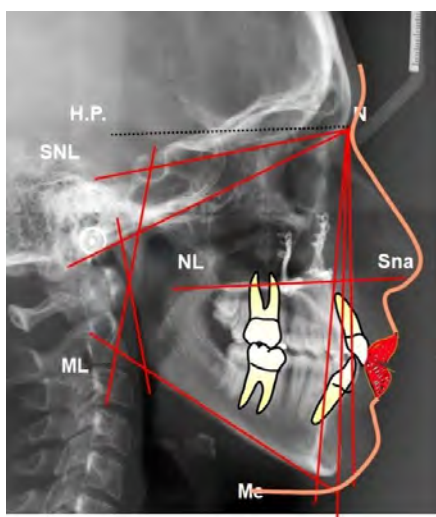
Lateral cephalometric radiograph (FRS) at the end of treatment
